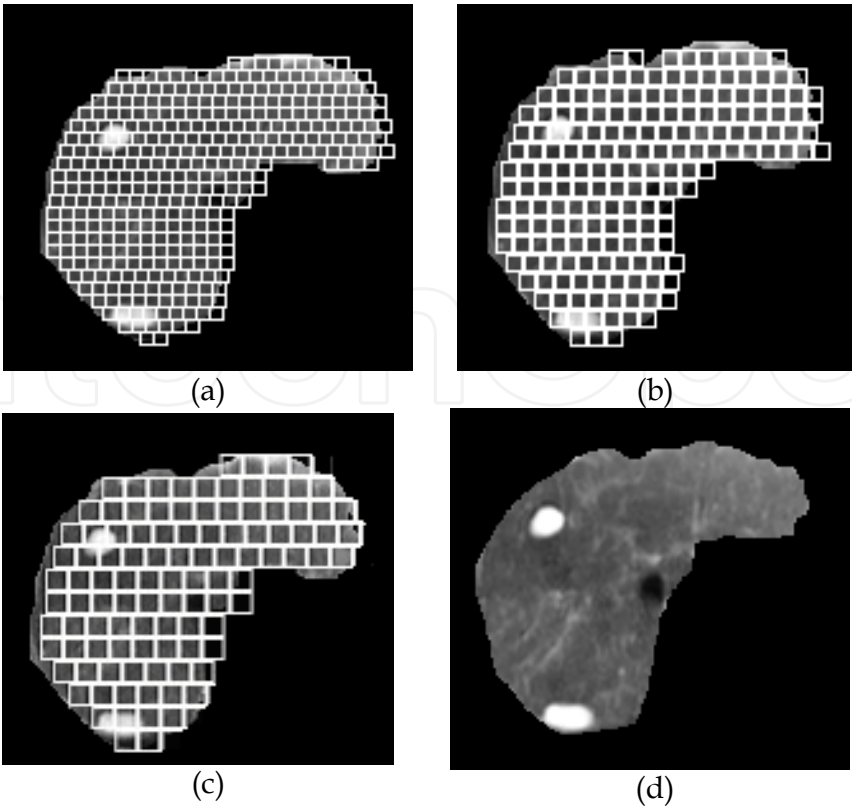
Automated segmentation of image block in a cyst liver boundary using (a) 5 x 5 (b) 8 x 8 (c) 10 x 10 image block (d) shows the liver region in MRI abdomen image.
